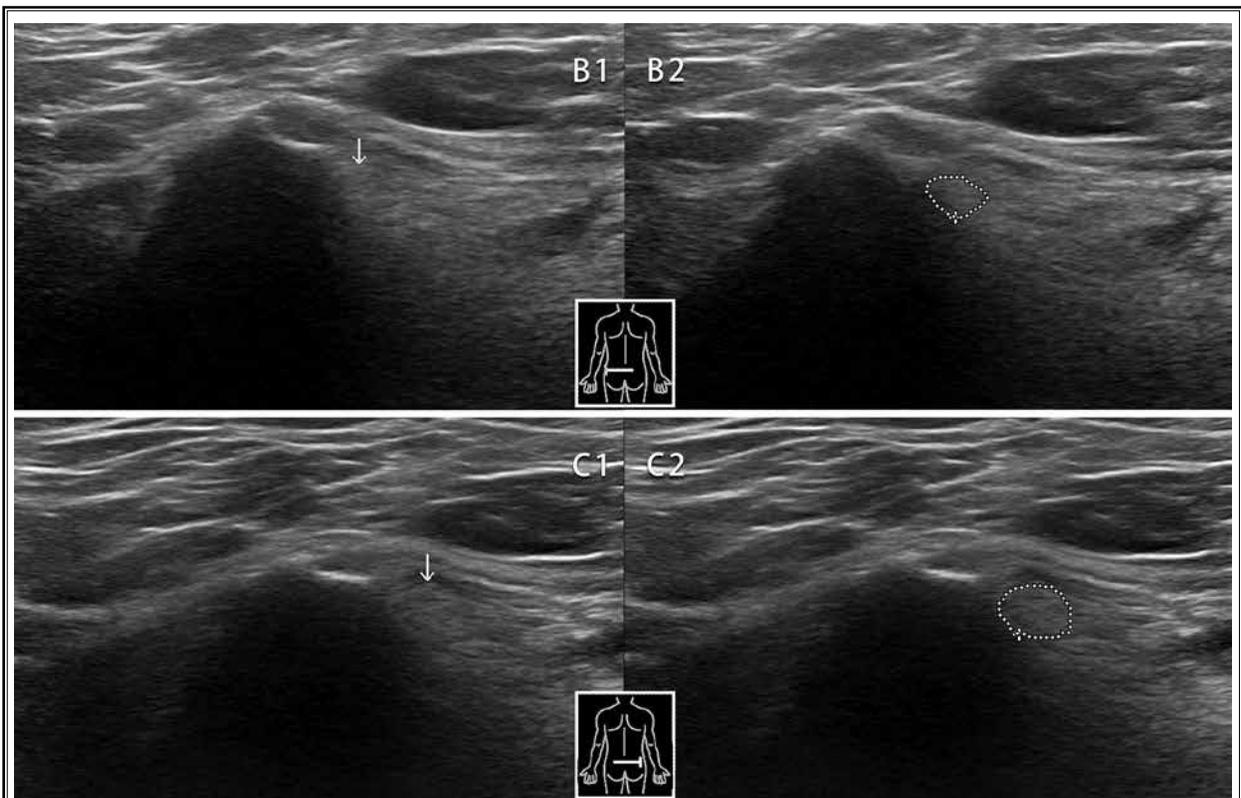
We conducted a postoperative ultrasound examination of the bilateral superior cluneal nerves in Patient 2 and observed that the right superior cluneal nerve had a significantly thicker medial branch than the left side did. B1: Normal position of the medial branch of the left superior cluneal nerve (indicated by the white arrow). B2: Cross-sectional contour of the normal medial branch of the left superior cluneal nerve (outlined in white dashes, with a circumference of 1.28 cm and a cross-sectional area of 0.112 cm²). C1: Thickened position of the medial branch of the right superior cluneal nerve (indicated by the white arrow). C2: Cross-sectional contour of the thickened medial branch of the right superior cluneal nerve (outlined in white dashes, with a circumference of 1.68 cm and a cross-sectional area of 0.201 cm²).
